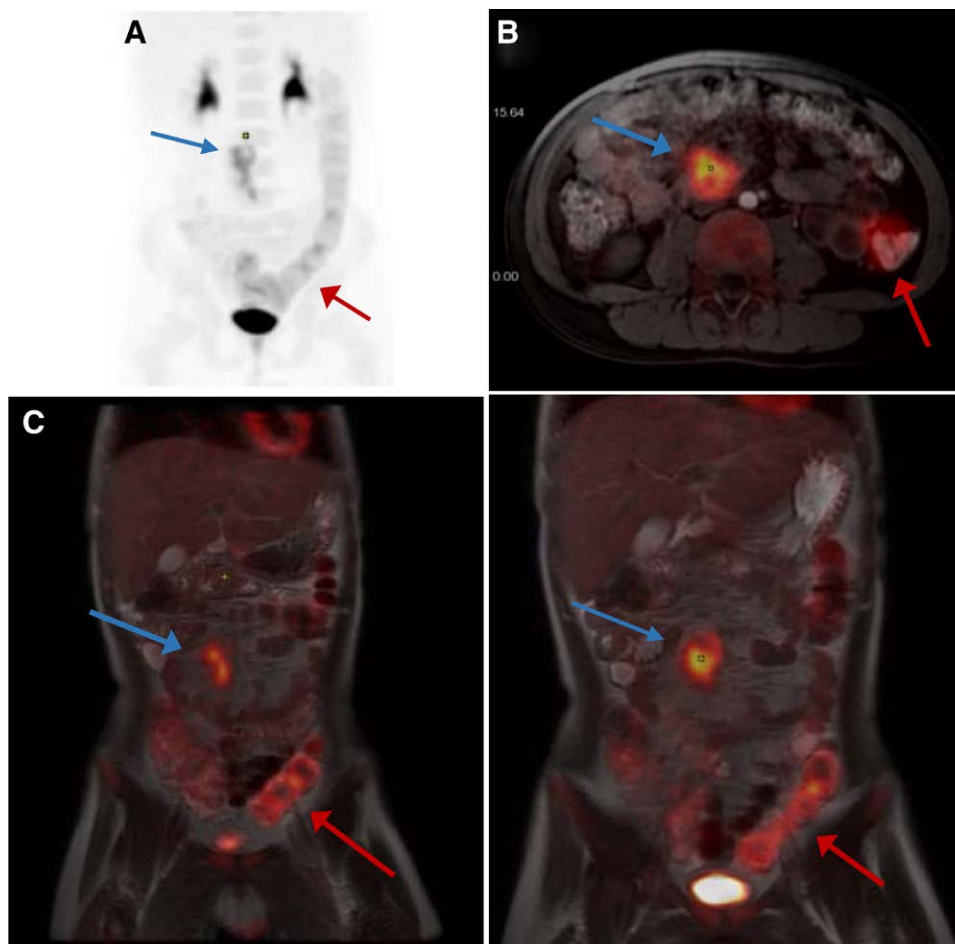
[18F]-FDG PET/MR images with pathological FDG uptake in an abdominal granuloma (blue arrow) and a thickened colonic bowel wall (red arrow) (FDG uptake in bladder, heart, and kidney are physiological). [18F]-FDG PET/MR = [18F]-fluorodeoxyglucose positron emission tomography/magnetic resonance.
